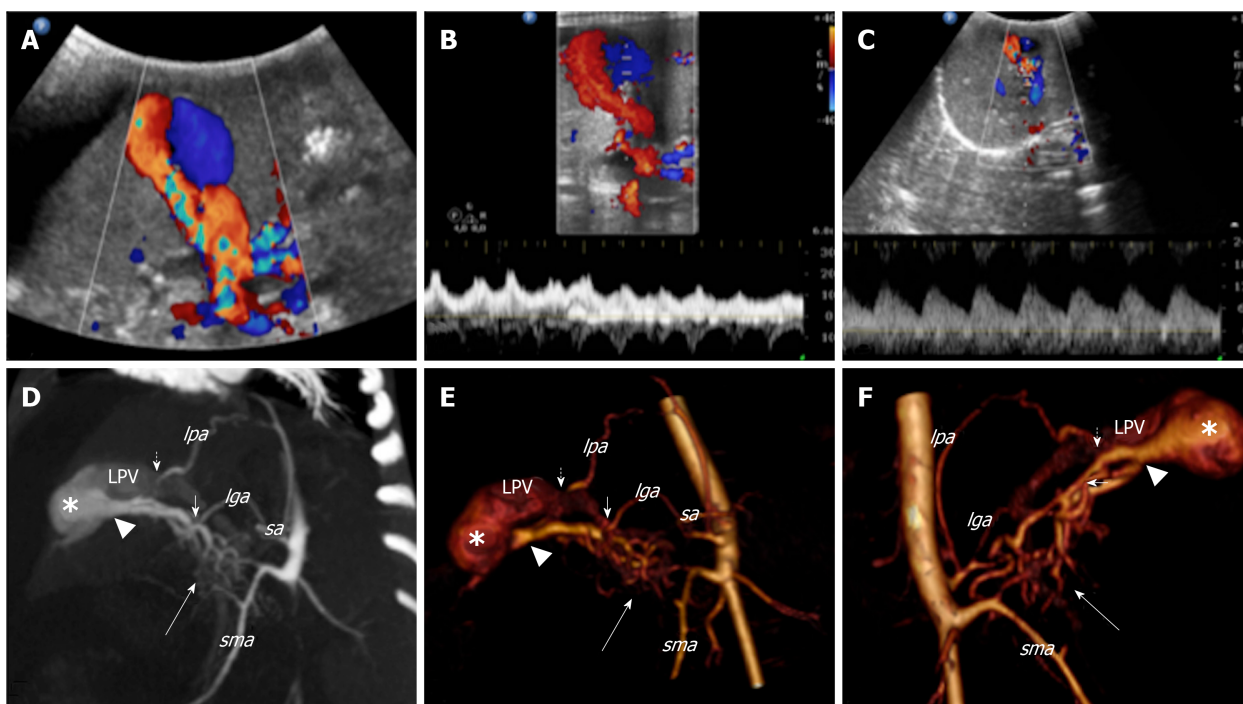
Colour Doppler ultrasound and computed tomography images that show the congenital intrahepatic arteriportal fistula. A: Colour Doppler ultrasound images of the liver revealed aneurysmal dilatation of the left portal vein with turbulent bidirectional flow; B: Particularly, the venous flow appeared arterIALIZED; C: Several dilated and tortuous branches of the hepatic artery with high flow rate supplied the dilated portal vein segment; D: Contrast enhanced multi-detector computer tomography images of the abdomen reformatted on both the left oblique: maximum intensity projection; E: 3D volume rendered; F: 3D-VR right oblique plane. Contrast enhanced multi-detector computer tomography shows the complex vascular malformation characterised by a dense dysplastic small arterial network that arose from the hepatic and superior mesenteric system (thick arrow) and directly converged to the left portal vein through one Y-shaped fistula within the Rex recess (arrow head). Two additional feeders to the vascular anomaly [from the phrenic (short dotted arrow) and left gastric (short arrow) artery, respectively] were also detected. lga: Left gastric artery; lpa: Left phrenic artery; sa: Splenic artery; sma: Superior mesenteric artery; LPV: Left portal vein.
